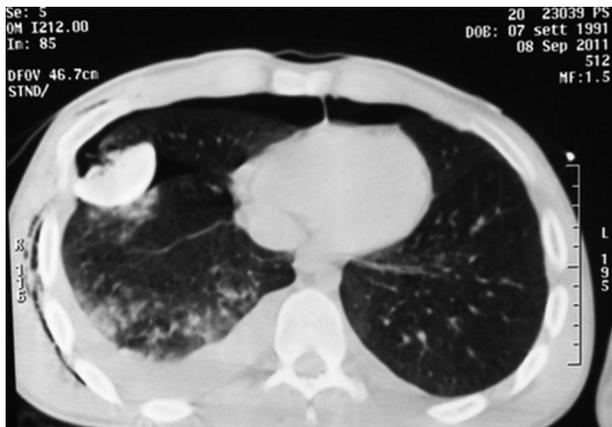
Computed tomography scan confirms right pneumothorax with intrathoracic humeral head migration.
